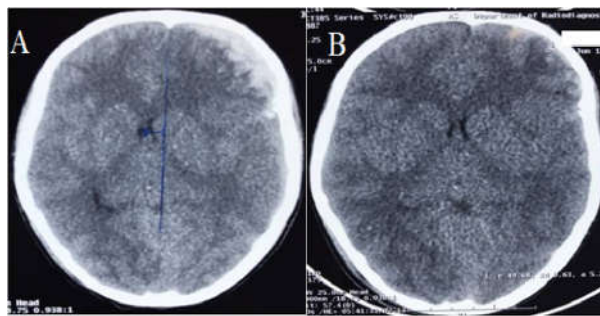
Case no.2 (A) initial CT head showing left side acute SDH, (B) repeat CT head after 19 hours having spontaneous resolution of SDH
